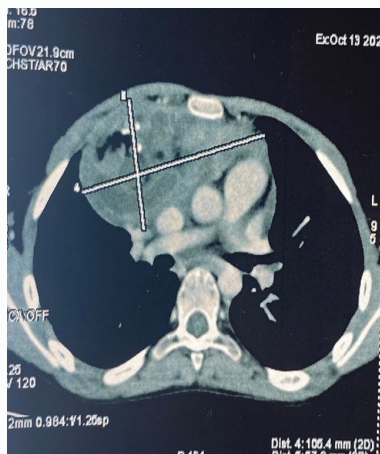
CT; Axial section of the mediastinal tumor.
